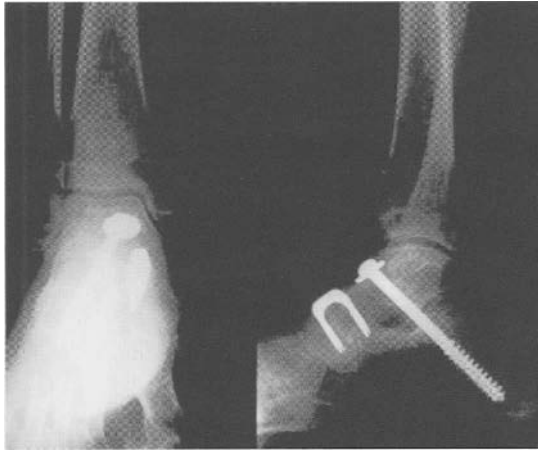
Arthrodeses talo-navicular and talo-calcaneal (X-ray a.p. and side view).
